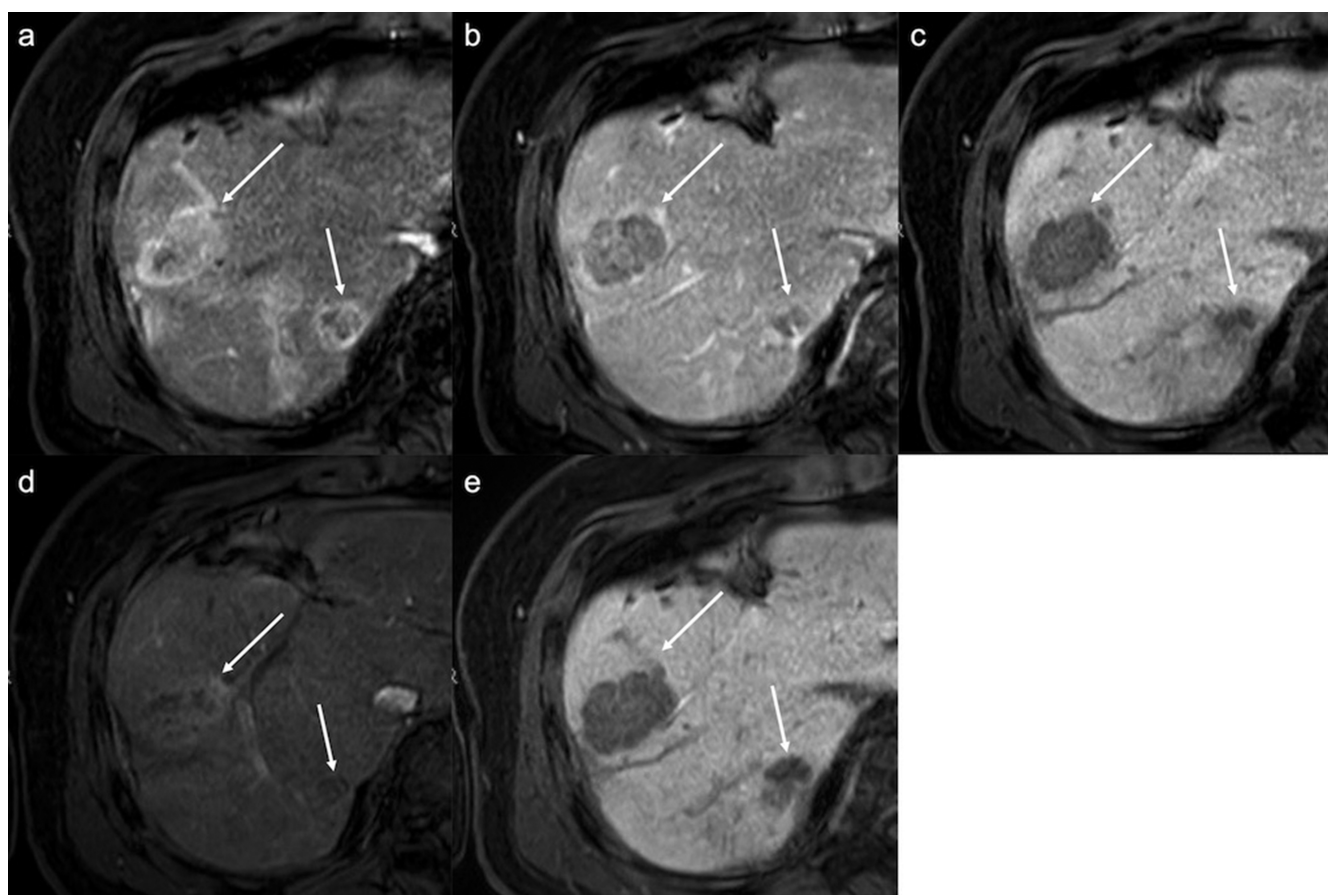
MR images from a 78-year-old male of multiple hepatocellular carcinomas treated with lenvatinib. The target lesion showed hyperenhancement in the arterial phase (a, arrows), and hypointensity in portal venous and hepatobiliary phases (b and c, arrows). Two months after the initiation of lenvatinib, the arterial phase hyperenhancement of these tumors decreased (d, arrows), but unchanged in size (e, arrows).
